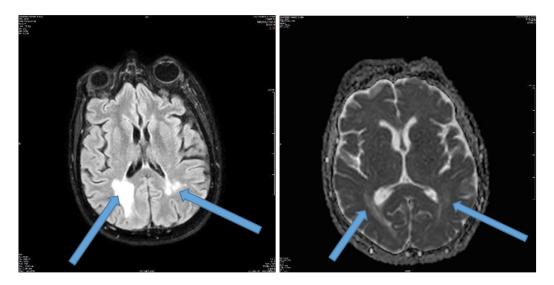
FLAIR and ADC from March 06, 2023.
